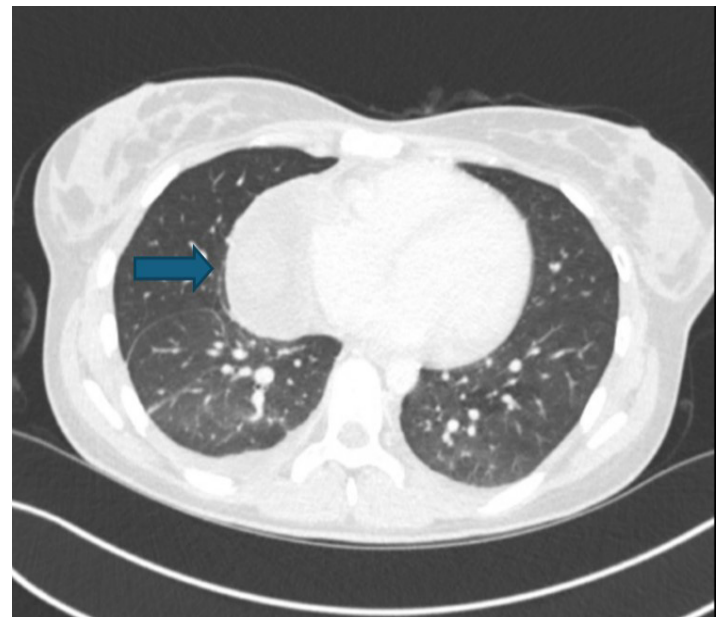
Cross-sectional CT scan of the thorax demonstrating the large mediastinal cyst closely associated with the heart.
